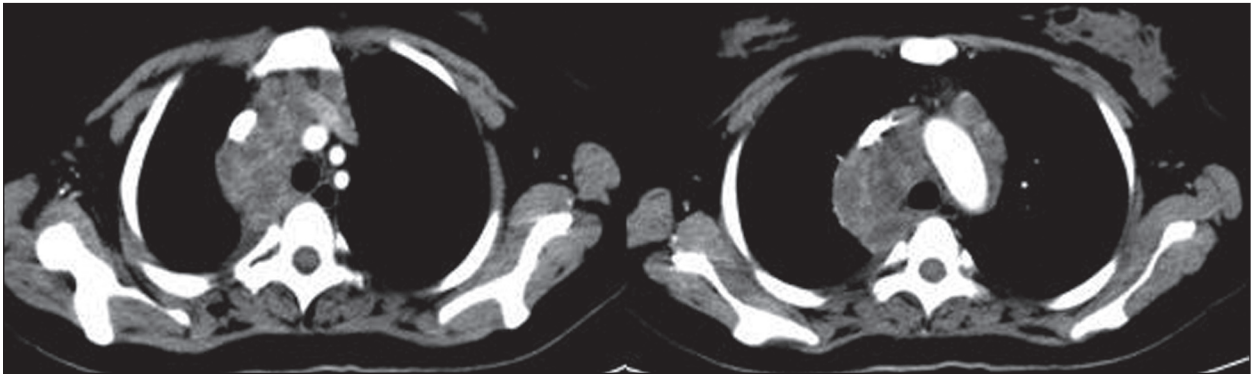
Contrast-enhanced thoracic CT scan showing enlargement of lymph nodes in mediastinum with heterogeneous contrast enhancement
